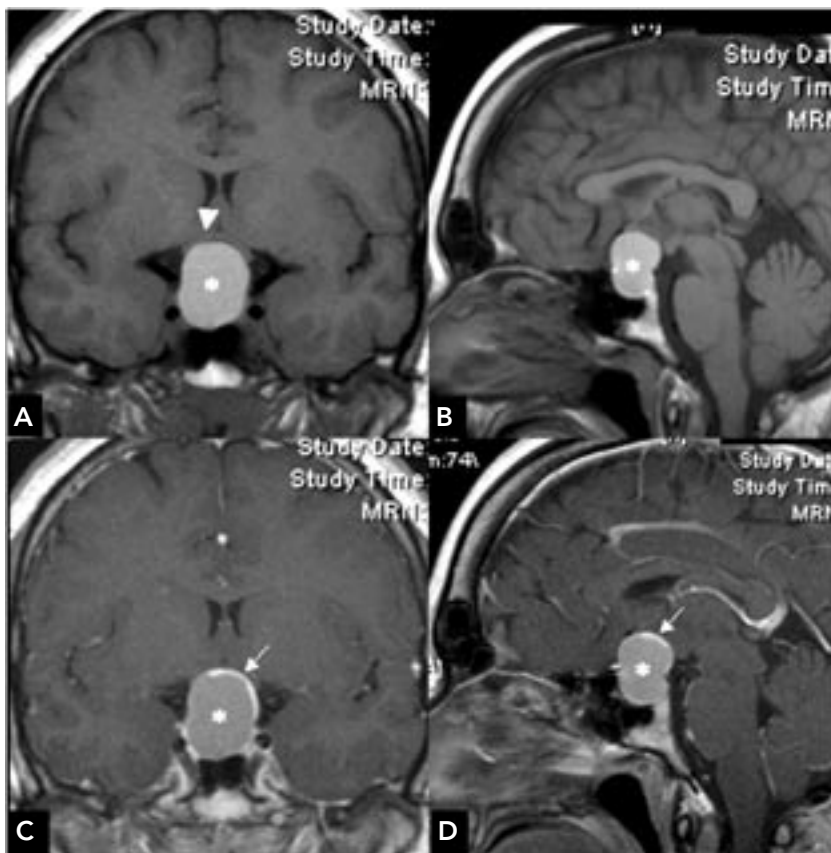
Sellar magnetic resonance imaging (MRI) of an intra- and suprasellar Rathke's cleft cyst (RCC), before (A, B) and after (C, D) iv administration of gadolinium-DTPA. Coronal (A, C) and Sagittal (B, D) images. The cyst (\*) appears as a homogeneous slightly hyperintense, non-enhancing intra- and suprasellar lesion. The optic chiasm (arrowhead) is displaced upward. The normal pituitary gland (arrow) is compressed and displaced upward and to the left. Pre-operatively, the patient had panhypopituitarism.
